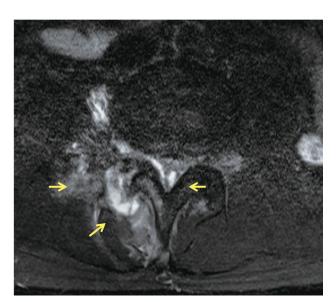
Magnetic resonance imaging lumbar spine with contrast, axial view: right L3/4 facet arthritis and adjacent abscess. (arrow)
